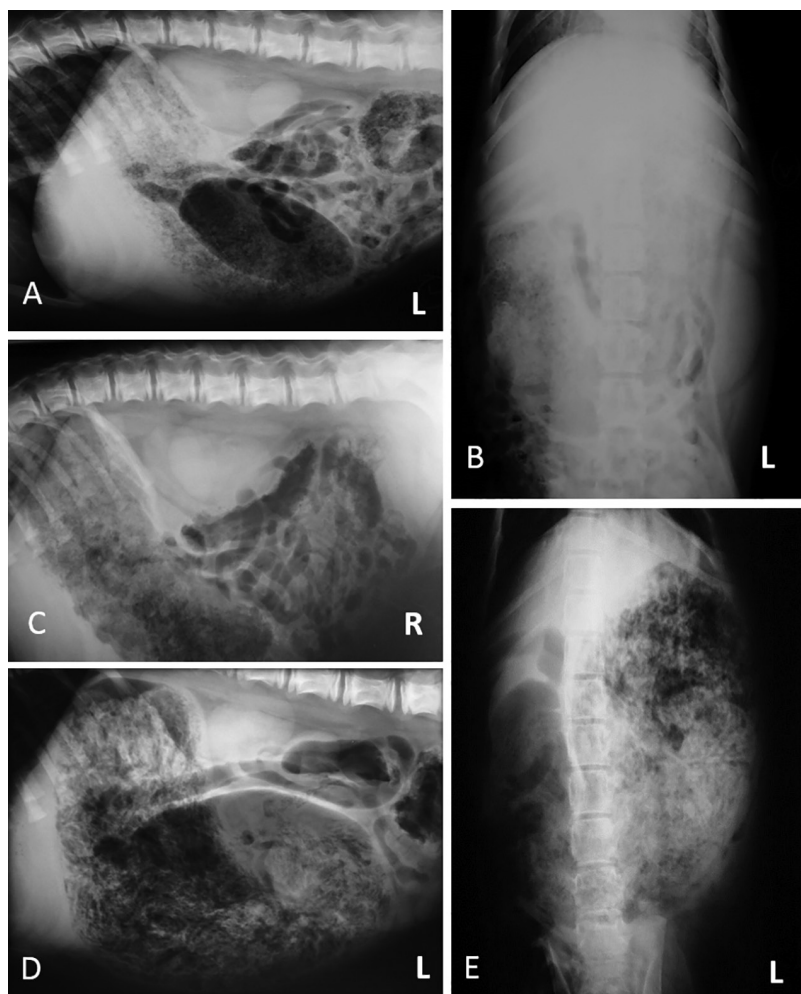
Lateral (A, C, and D) and ventrodorsal (B and E) abdominal radiographic views of a 6-month-old sexually intact male Malayan tiger (*Panthera tigris jacksoni*; A to C) and a 6-month-old sexually intact female Sumatran tiger (*Panthera tigris sumatrae*; D and E) with gastric dilatation. Notice that the stomach appears markedly distended with ingesta and gas in all images. L = Left. R = Right.
